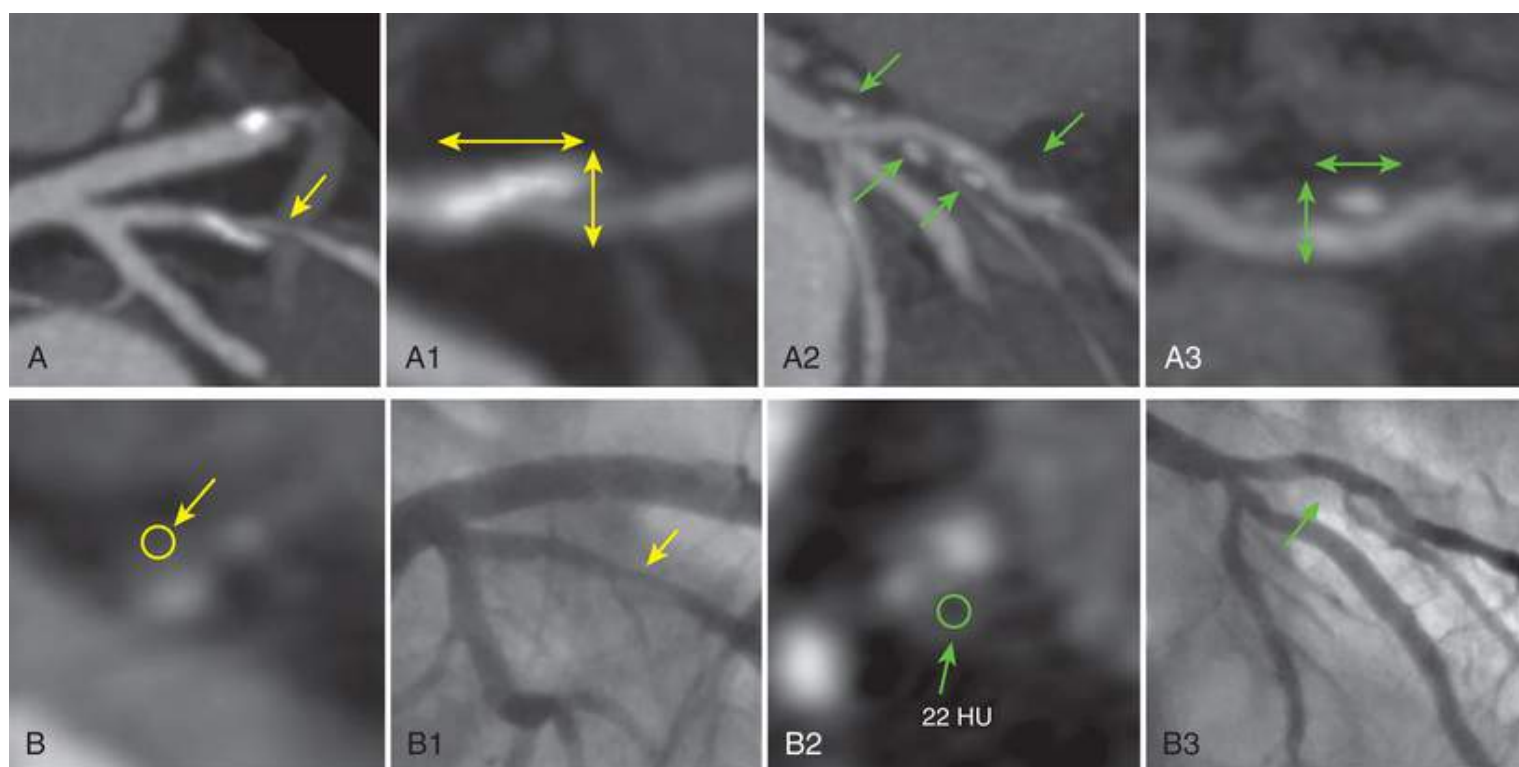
Relationship of atherosclerotic plaque characteristics (APCs) and coronary ischemia in two patients (A, B) undergoing CCTA, invasive coronary angiography (ICA), and atherosclerotic plaque evaluation. Patient A has high-grade stenosis from a single calcified plaque (A1), with no positive arterial remodeling (A2) and no low-attenuation plaque (Hounsfield unit [HU] density >30) (A3). Despite the severity of the stenosis confirmed by ICA, fractional flow reserve (FFR) demonstrates no ischemia with a value >0.80. In contrast, patient B demonstrates no significant stenosis but numerous atherosclerotic plaques with spotty calcifications (B1) that display positive arterial remodeling (B2), and low attenuation (HU <30) (B3). ICA confirms the absence of high-grade coronary stenoses. Despite this, coronary ischemia is present by an invasive FFR value of 0.76. (Modified from Park HB, Heo R, O'Hartaigh B et al. Atherosclerotic plaque characteristics by CT angiography identify coronary lesions that cause ischemia: a direct comparison to fractional flow reserve. *JACC Cardiovasc Imaging* 2015;8:1-10.)
